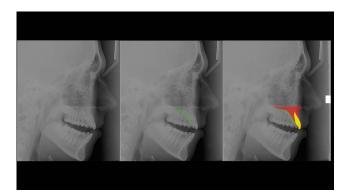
Radiographic lateral head film of patient fitted with a thermoplastic PETG bite registration, with radiopaque markers positioned along the palatine raphe; identification of the profile of palatal mucosa and of the maxillary bone.
